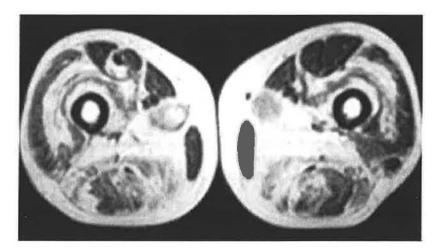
T1-weighted image of proximal thigh muscles in PM. Extensive fat infiltration is especially notable in the posterior compartment.
